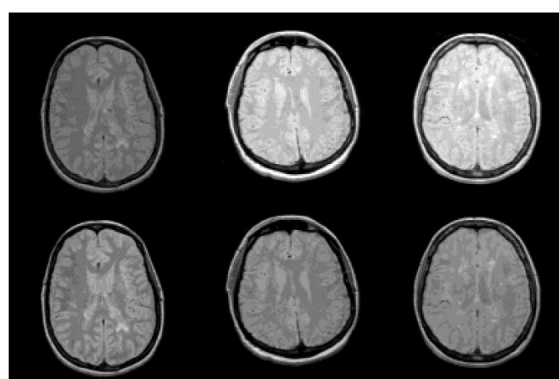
The first row of images correspond to the original MRI images and the second row is the result of standardization method proposed by Nyul et al. Image adapted from [29].
